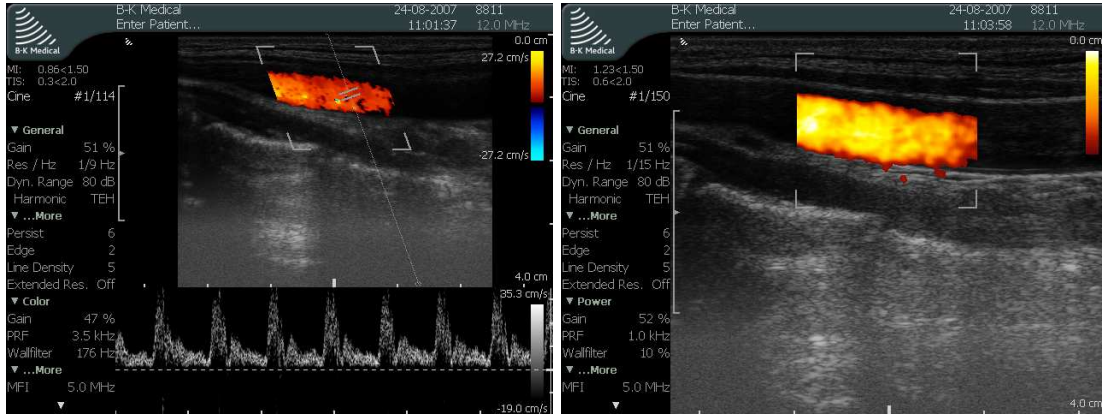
Display modes. Triplex imaging (left) and Power Doppler (right)
